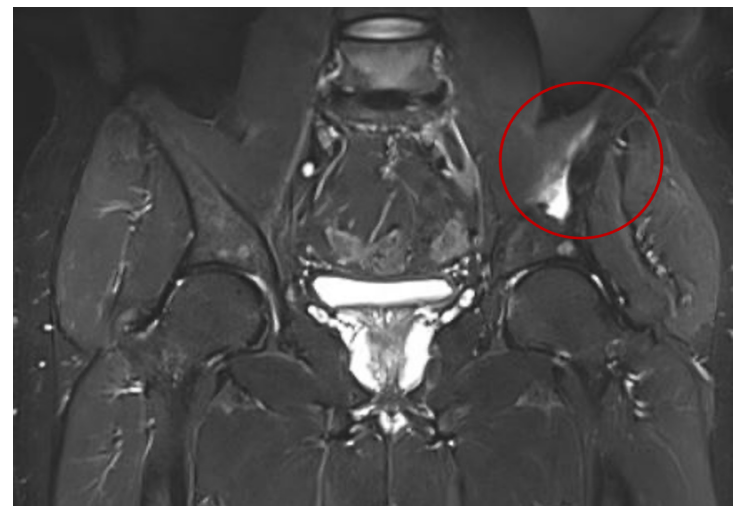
Representative section of MRI at 9 months follow up demonstrating significant regression of lesion.
